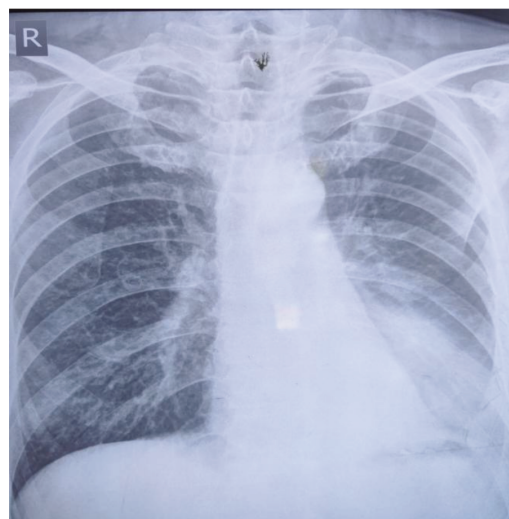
Chest radiograph showed a uniform left lower zone opacity which was retro cardiac in location.
